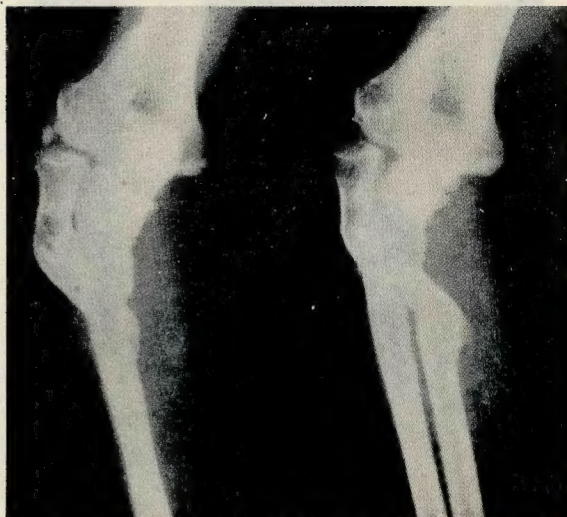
(Record No. 53, I.S.N. 780068) Roentgenogram showing malunion of upper third of right ulna and radius.
